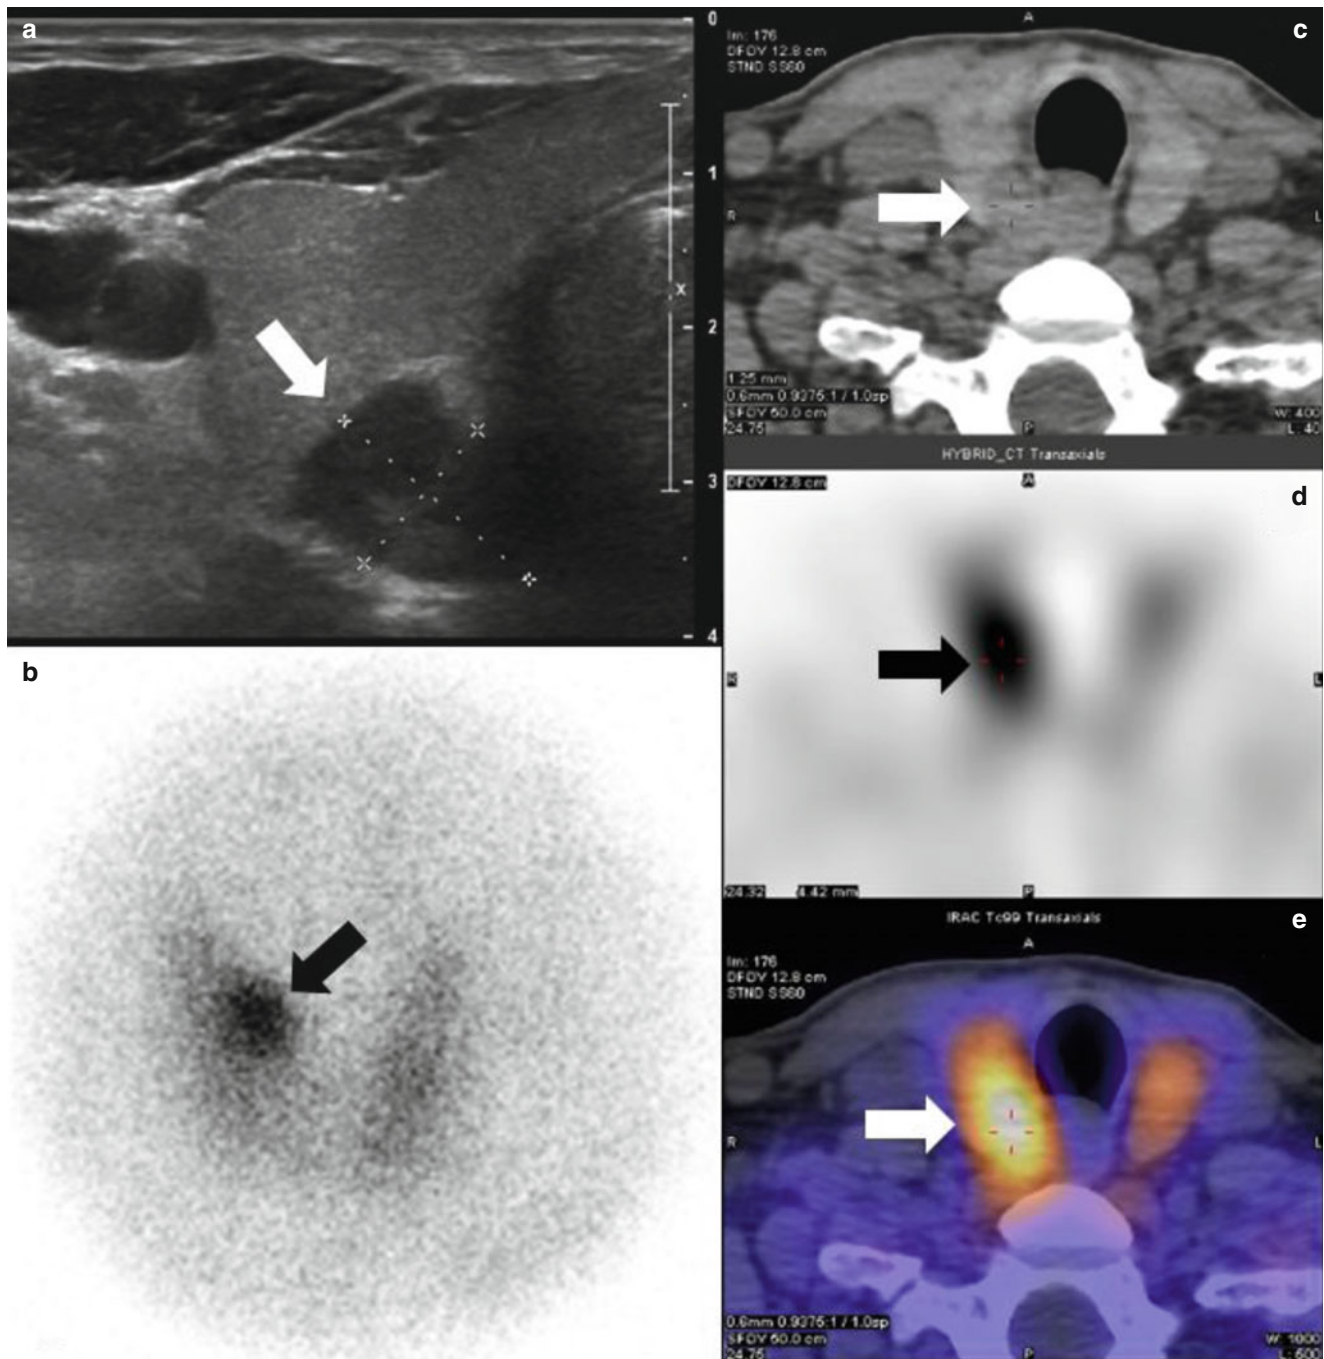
Ultrasound (a), planar ^{99m}Tc -MIBI scintigraphy (b), and hybrid ^{99m}Tc -MIBI SPECT/CT (c–e) of a parathyroid adenoma located behind the right lobe of the thyroid (arrows). The transversal ultrasound images
